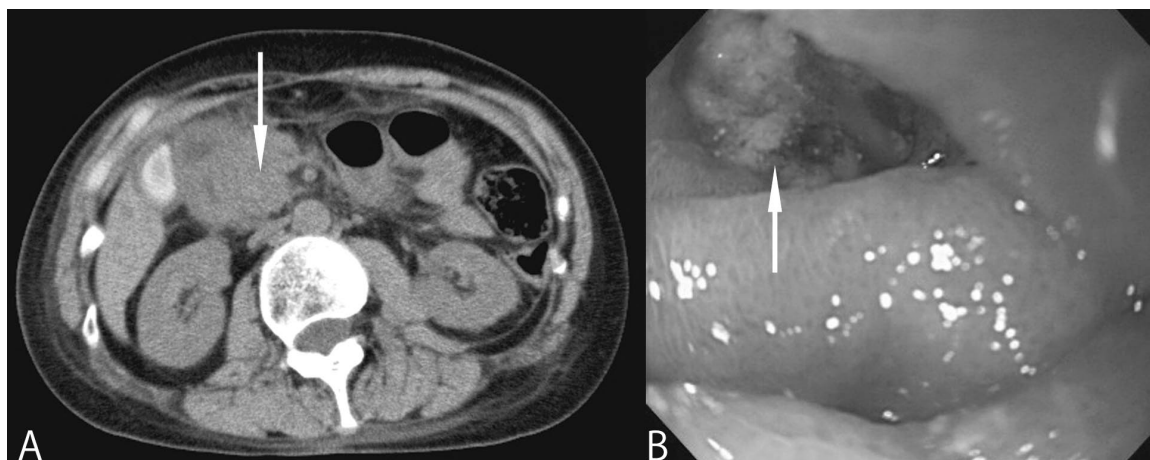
Abdominal CT (A) showed a mass in the head of the pancreas (arrow). On endoscopy of the papilla of Vater, a tumor was seen (B, arrow).
